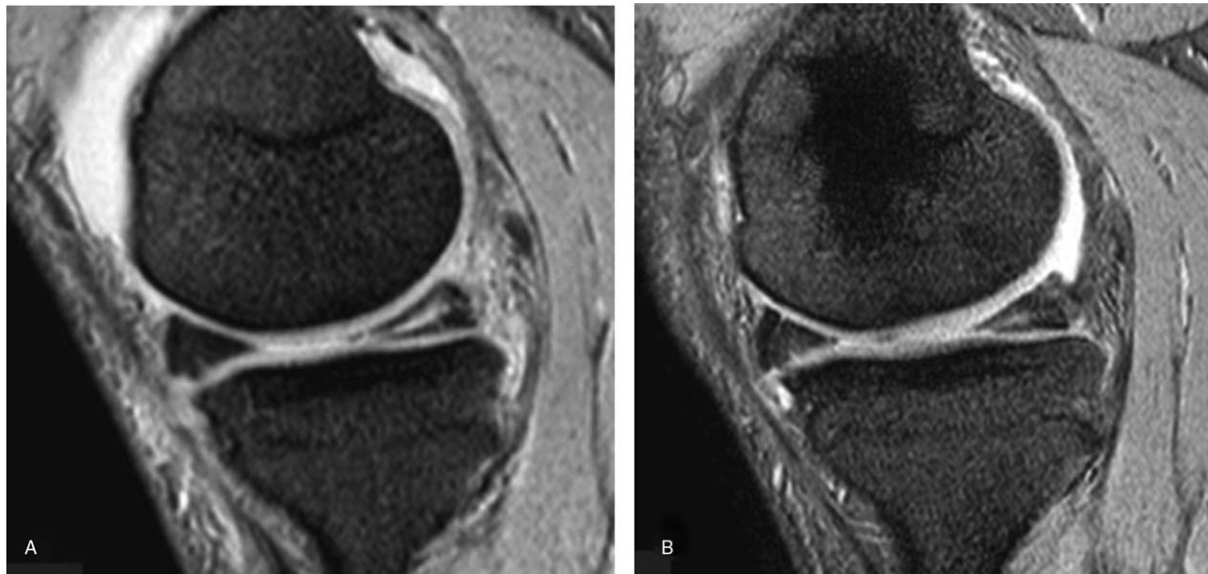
MRI images of representative case (Case7) (A) Before surgery: high signal intensity of a horizontal tear extending from the joint capsule to the articular surface. (B) After surgery: signal intensity is low near the free edge as well as near the joint capsule.
